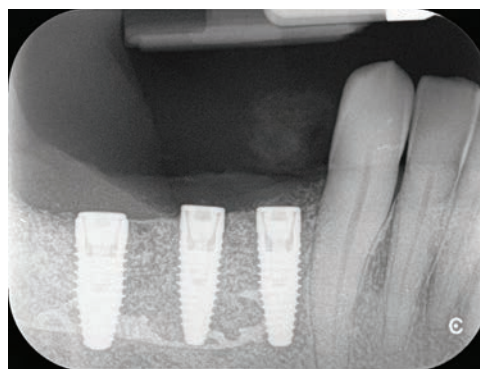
Peri-apical x-ray at implant installation
